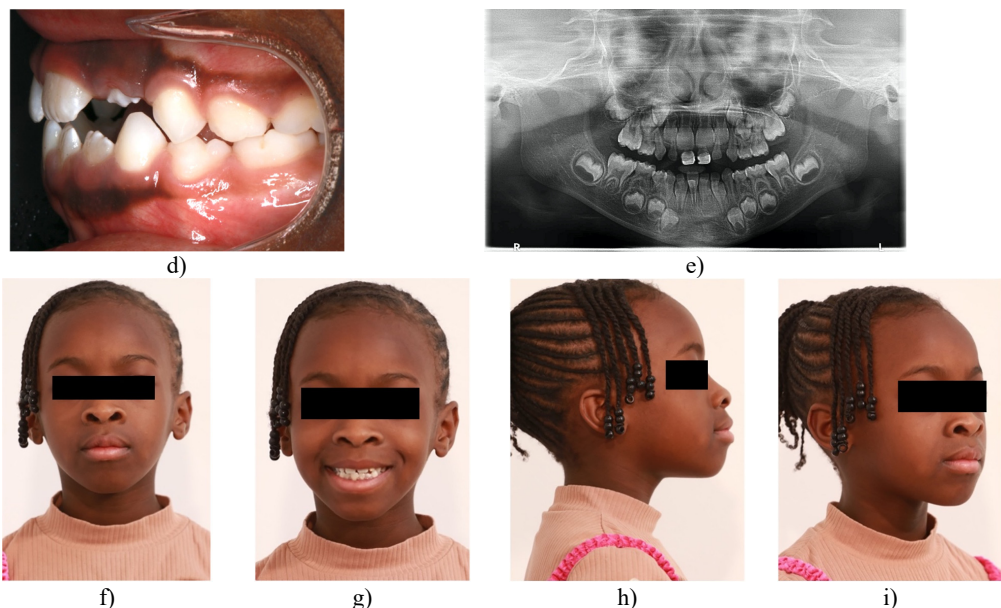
Follow-up pictures after 31 months: a)-d) intraoral pictures; e) panoramic X-ray, f)-i) facial pictures
